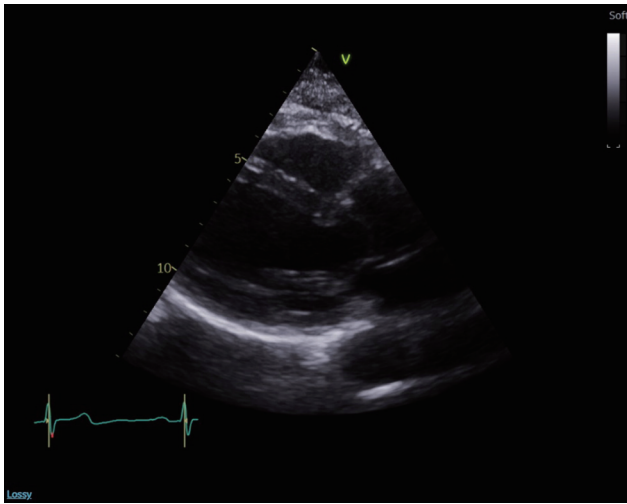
Echocardiogram showing resolution of left ventricular function with some degree of left ventricular hypertrophy.
